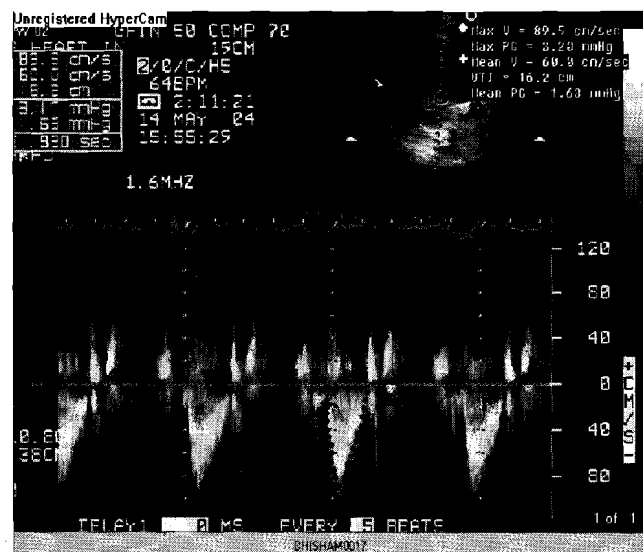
(b): Apical four chamber view showing pulse wave across aortic valve, since blood flow is from LV to aorta i.e. away from transducer therefore shows negative trace.
